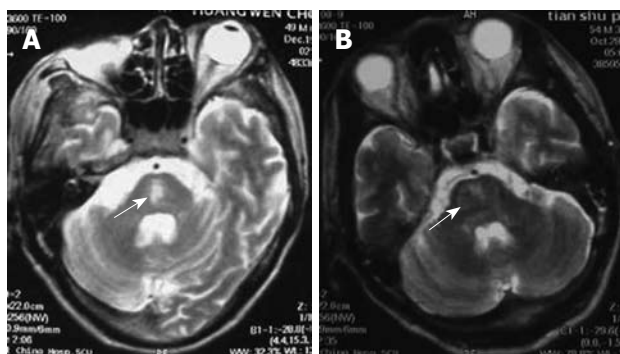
Magnetic resonance imaging displayed high-signal intensity on T2-weighted images of the central pons 9 d (A) and 8 d (B) after surgery (arrows).
